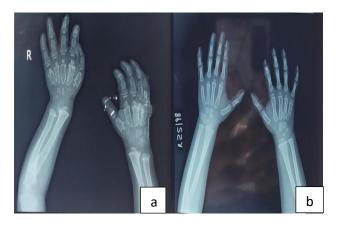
a) X ray of forearm and wrist with phalanges shows bullet shaped phalanges, broad metaphysis & proximal narrowing of the metaphysis, b) X-ray forearm and wrist with phalanges of the normal twin which shows no abnormalities.
